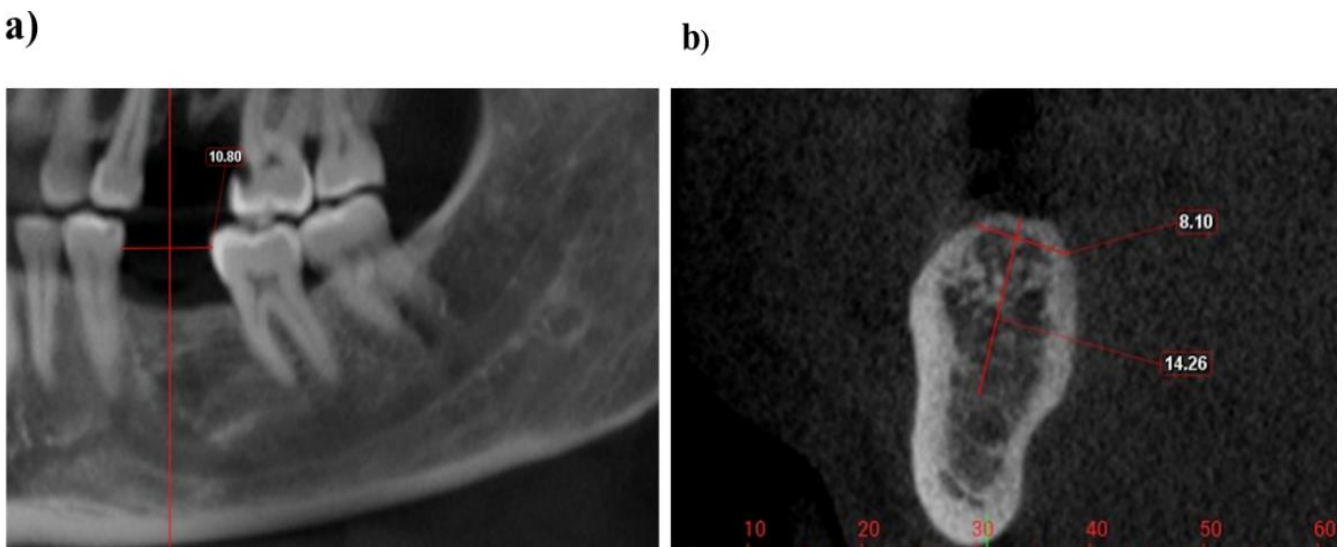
Radiographic examination; a) Mesio-distal evaluation; b) Measurement of bone width, height.
